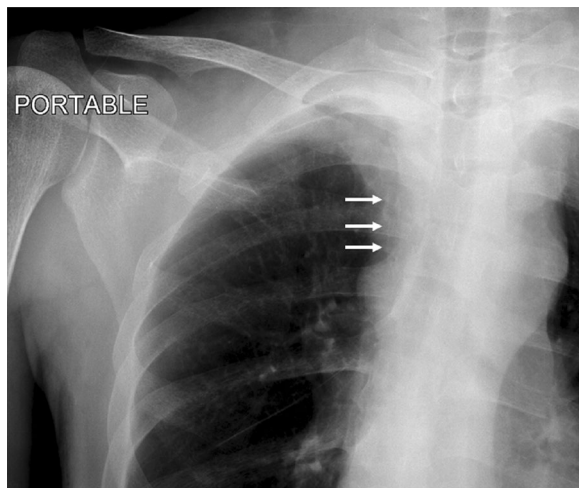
Retrospective examination of the initial chest radiograph showed a faint calcified tubular structure in the right paratracheal region (white arrows) corresponding to the calcified fibrin sheath
